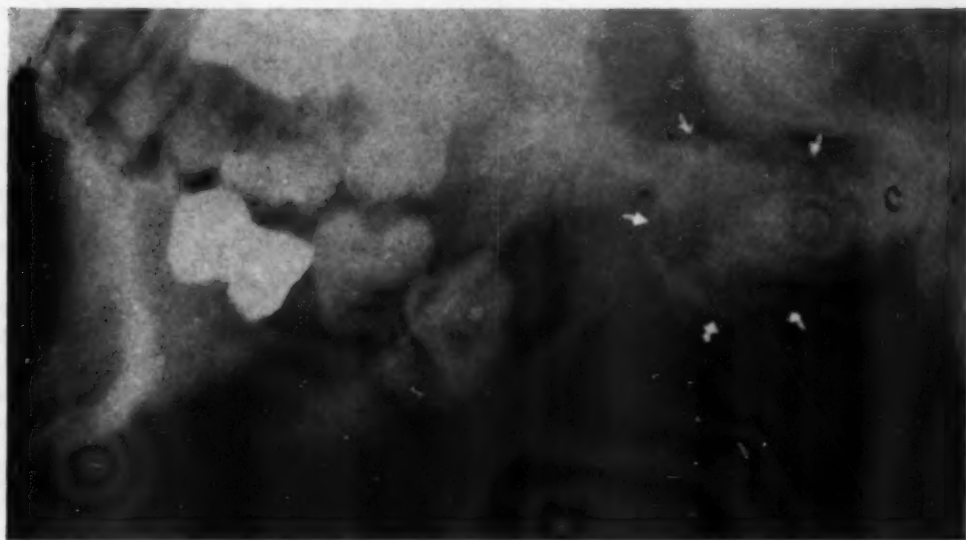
Lateral x-ray showing hyperostosis of right mandibular joint. Note condyle, C. (From Thoma and Kalil: AM. J. ORTHODONTICS AND ORAL SURG. [ORAL SURG. SECT.] October, 1943.)
